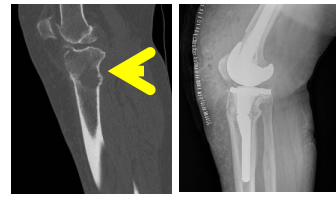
Sagittal CT image of the right knee demonstrates a lytic destructive lesion in the proximal posterior metaphysis with expansion of the posterior cortex with a pathologic fracture. CT, computed tomography
